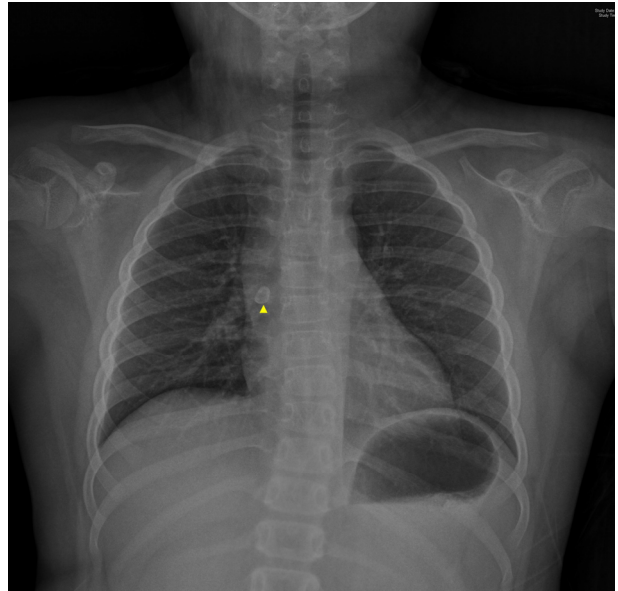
Chest X-ray demonstrating the presence of the tooth lodged in the right bronchus. No effusion or structural abnormalities are observed. (Yellow triangle: aspirated tooth)
